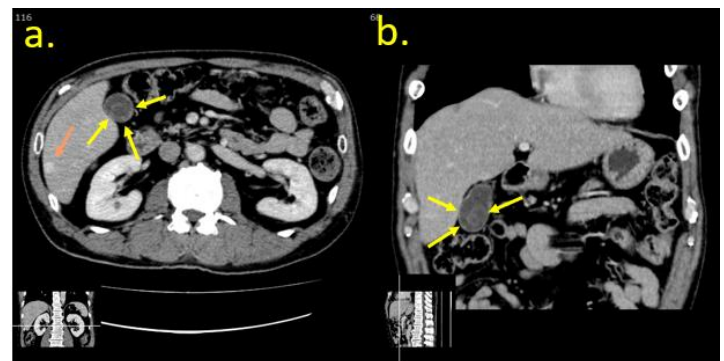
Enhanced abdominal CT scan (late phase)
